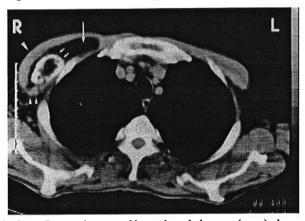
Computed tomographic cut through the mass (arrow), shows its location between the pectoral major muscle (one arrowhead) and the pectoral minor muscle (double arrowheads). The hypodensity of the mass reflects its lipomatous nature. Within the mass, an area of calcification can be depicted (double arrows).
